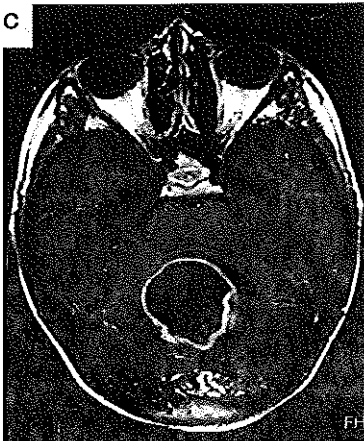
T1 - weighted gadolinium enhanced MRI images, of the tumors of patients C6 (A,a), C7 (B,b), and C8 (C,c). A,a show a large vermian tumor and an associated hydrocephalus. B,b show a tumor in the cerebellar vermis, compromising white matter and compressing the fourth ventricle. The tumor has dorsally cystic components and there are gross calcifications in the solid part of the tumor. C,c show a large cystic tumor, located medially in the fourth ventricle.
